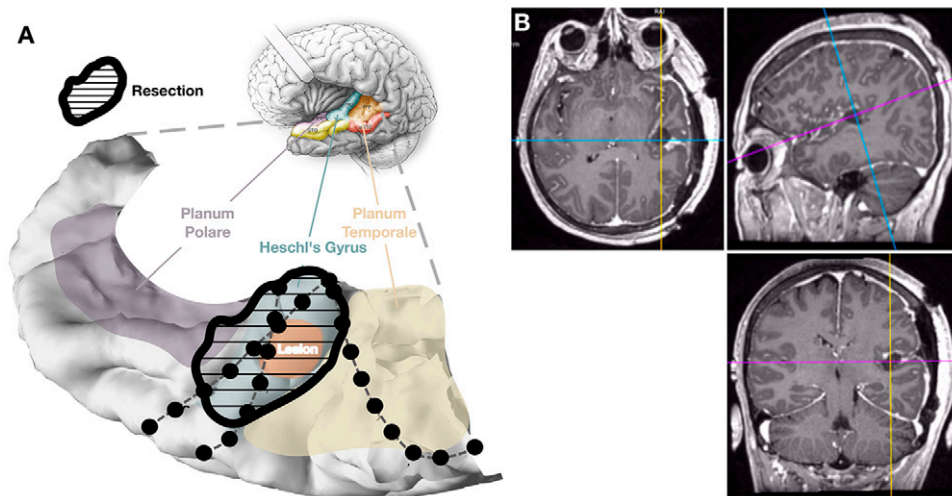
Postoperative MR image and temporal plane reconstruction showing the resection margins with full removal of the lesion and Heschl's gyrus. A: Reconstruction of the superior temporal plane with the true resection margins. B: Postoperative T1-weighted axial, sagittal, and coronal MR images showing the resection cavity. MR = magnetic resonance.
